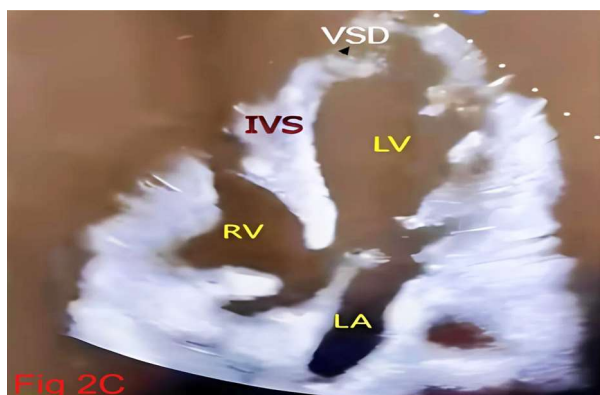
Shows an echocardiography image of the index patient revealing a large VSD.
